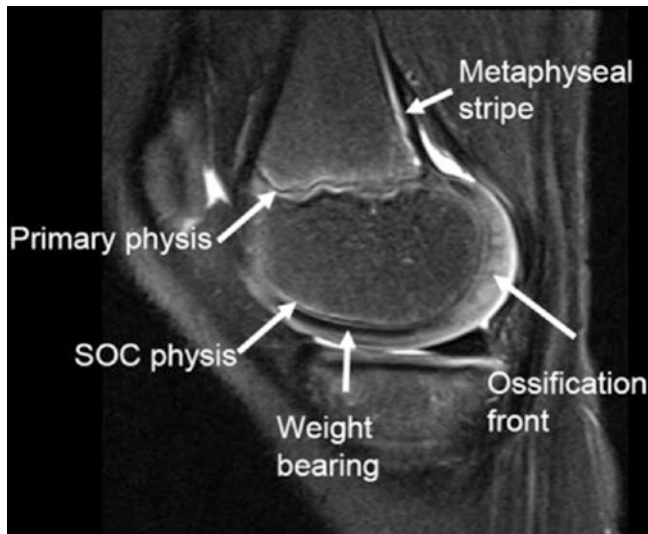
Normal MR signal variation in a 7-year-old boy. Sagittal T2-weighted image with fat suppression shows the normal trilaminar primary and secondary (SOC) physes. Low signal intensity in the weight-bearing epiphyseal cartilage is thought to be due to desiccation of free water, while higher signal in the posterior cartilage relates to the metabolically active ossification front. The image also shows the normal hyperintense metaphyseal stripe reflecting vascular tissue between the periosteum and subchondral bone. Axially, this structure is circumferential and has the appearance of a metaphyseal ring or collar (not shown)
